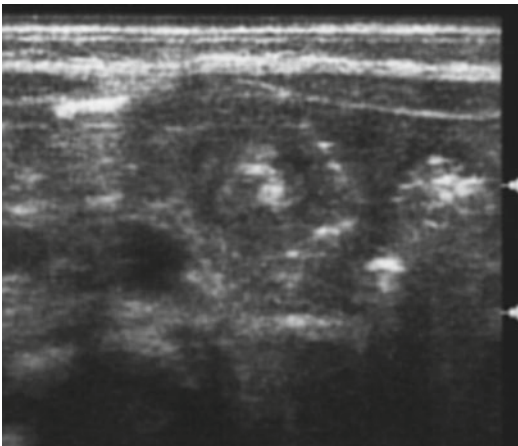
Whirlpool sign. The SMV and the mesentery wrap around the SMA on an axial-oblique plane sonogram in malrotation with volvulus
